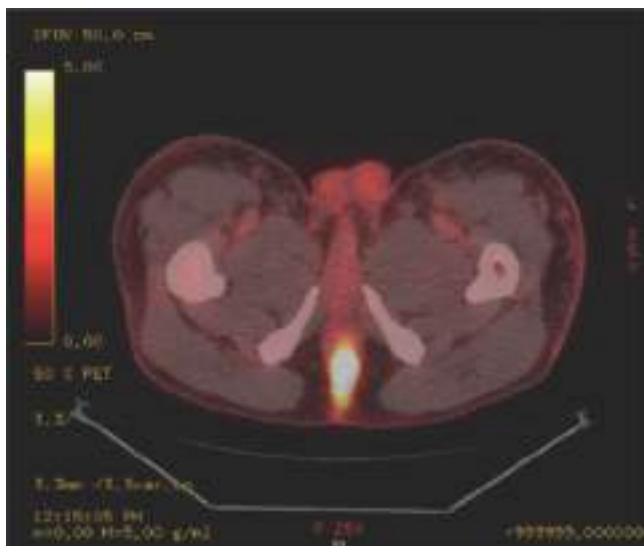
Anal cancer: pretreatment SUV = 18.1.
